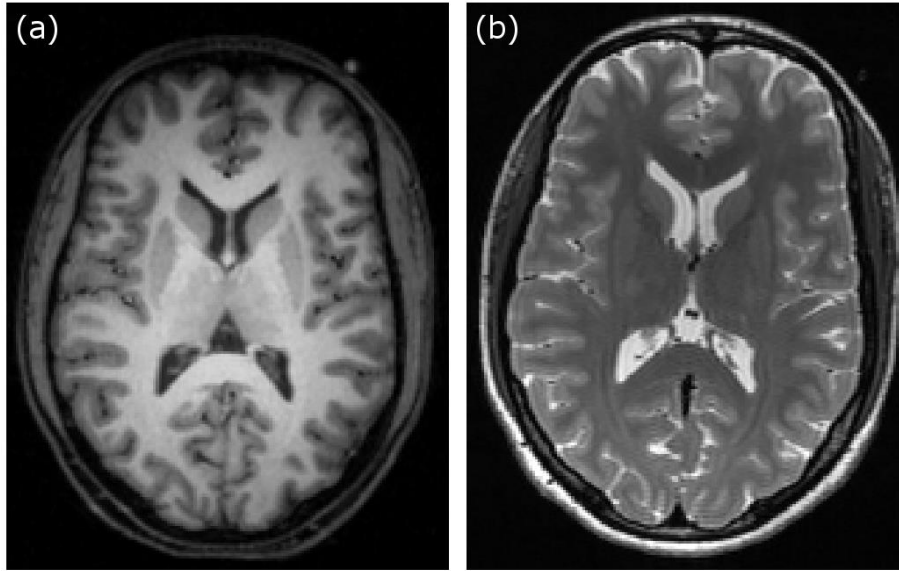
Axial view of a  $T_1$  and a  $T_2$  image. The composition of the tissue is the source for the contrast in MRI. In (a) the light areas correspond to white matter areas. The grey areas show the grey matter, while the CSF shows no signal and is therefore dark. In (b) the dark areas correspond to white matter areas. The light areas show the grey matter, while the CSF shows a high signal and therefore is white.
